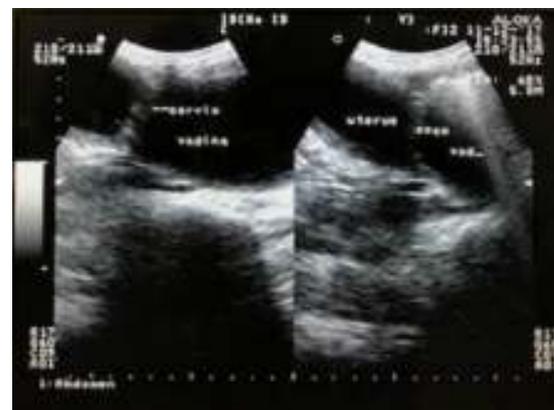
Ultrasonic picture of fluid filled vagina and uterine cavity*
